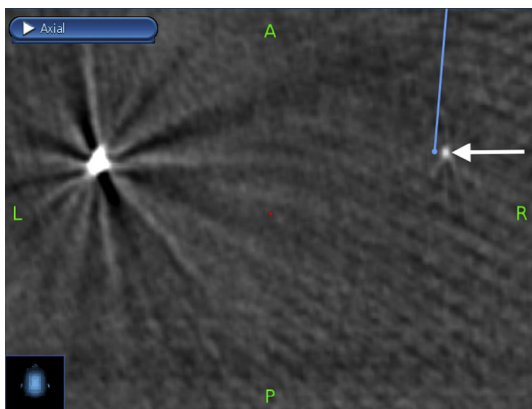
Intraoperative CT showing the visualized location of the microelectrode tip (long arrow) in relation to the planned trajectory (line). The DBS lead implanted into the left Gpi can also be seen at the left of the figure.
